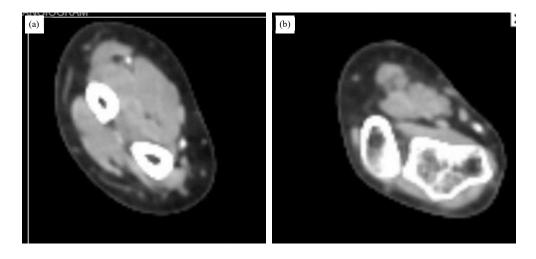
(a-b): CT Upper extremity angiogram of patient with crohn's disease having bluish discoloration of fingers
